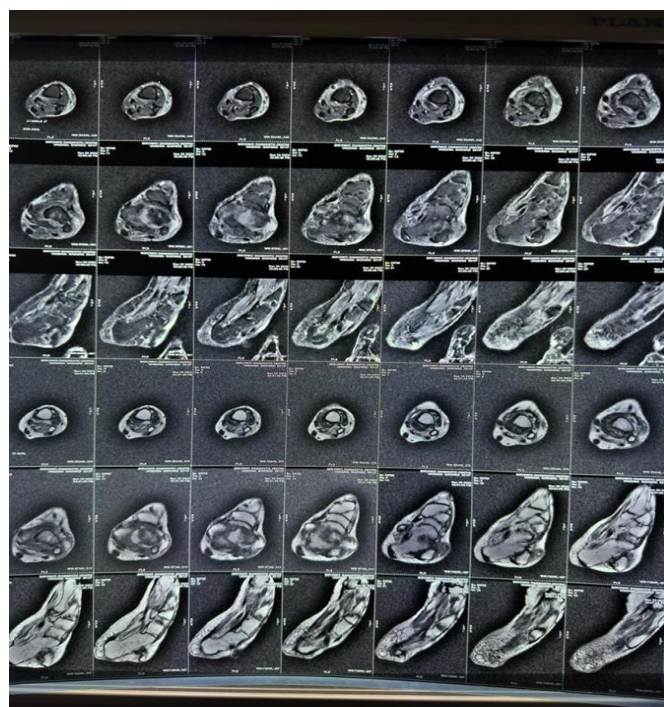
MRI T1-weighted and T2-weighted sagittal and axial images of the left ankle demonstrating severe arthropathy, talar subluxation, bone marrow edema, and soft tissue swelling.
